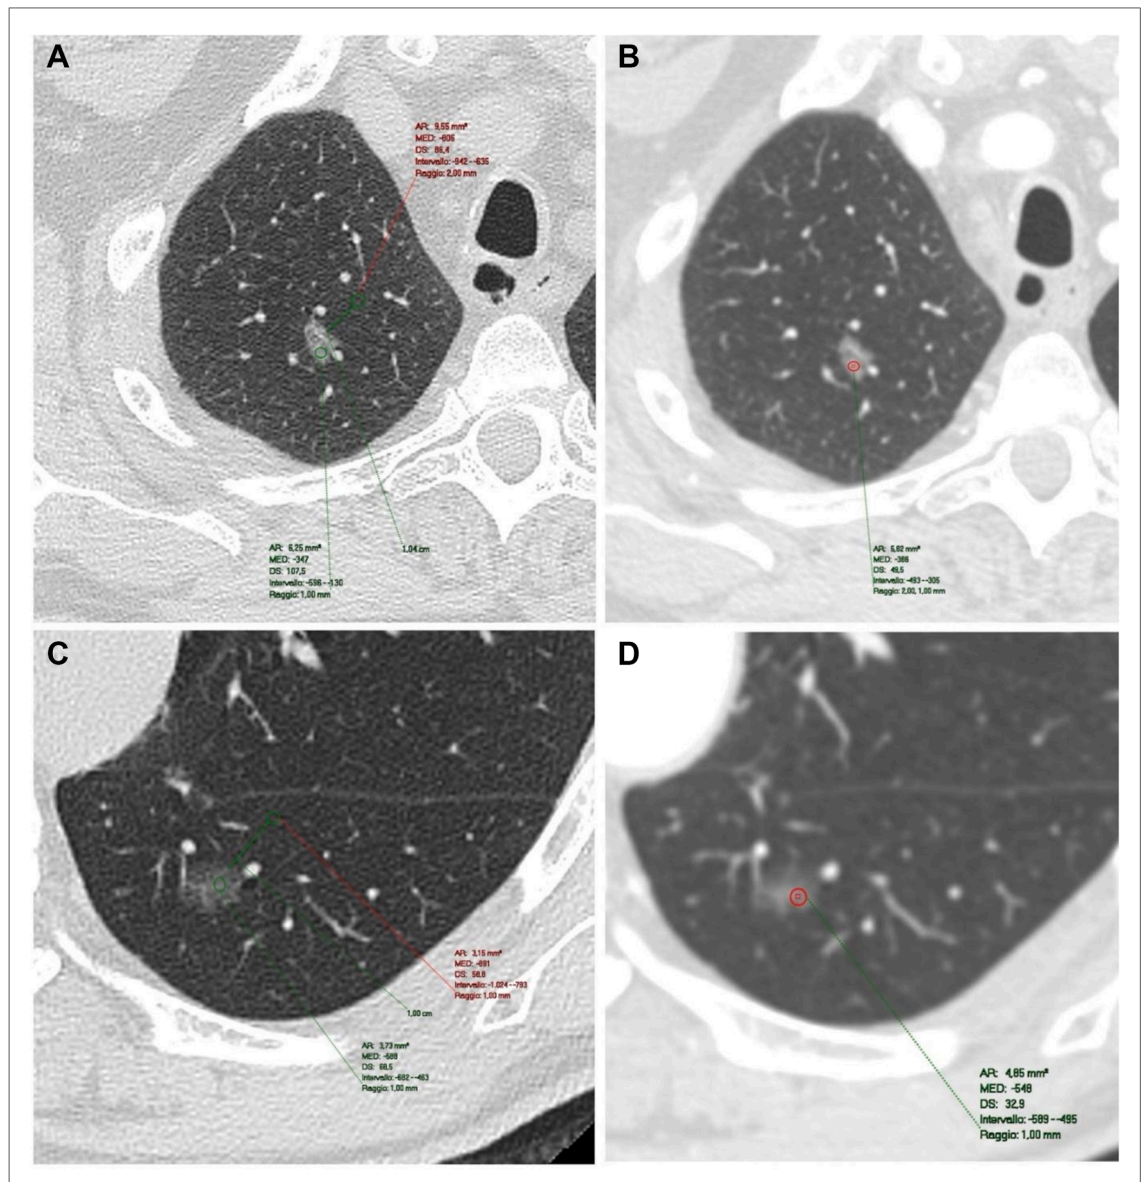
Radiologic evaluation in preoperative computed tomography (CT) scan. The upper images show the (a) unenhanced and the (b) postcontrast CT acquisitions of an invasive adenocarcinoma (IAC), whereas the lower images display the (c) unenhanced and (d) postcontrast phases of an adenocarcinoma in situ (AIS). The region of interest in the nodule highlights the differences in density between IAC and non-IAC both in the unenhanced (a: -347 Hounsfield units [HU] vs c: -588 HU) and postcontrast phase (b: -386 HU vs d: -548 HU). In images a and c, an additional region of interest is placed in the surrounding normal parenchyma to obtain the parenchyma attenuation necessary for the calculation of the difference CT value and relative attenuation.
